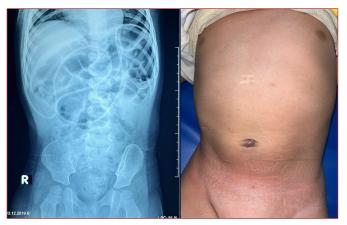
X-ray imaging on distal peritoneal catheter coiled at lower
